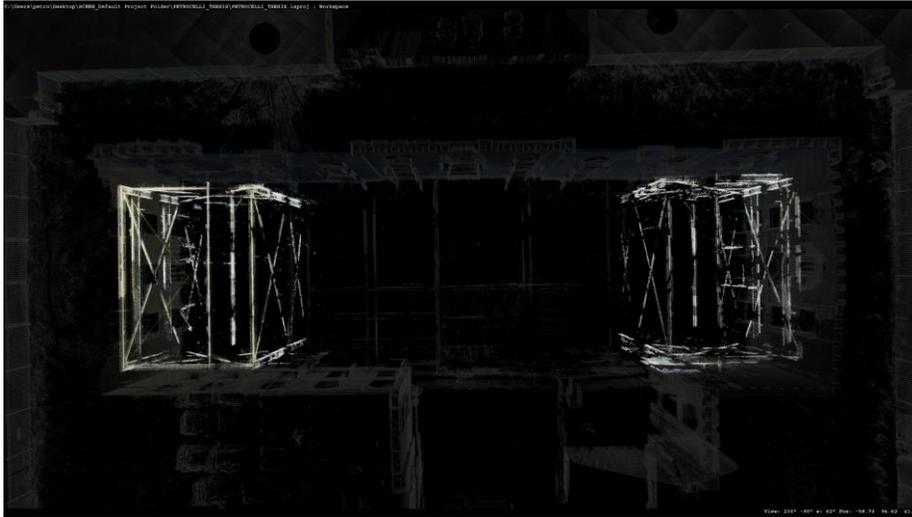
Smallpox Hospital | Southern Wing Xray
